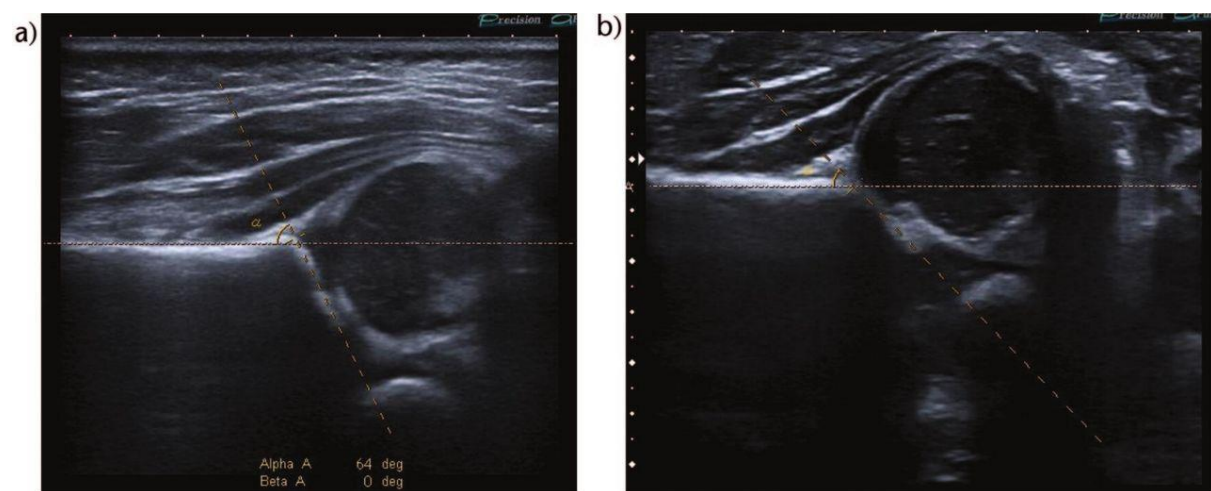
(a) Normal sonography. (b) In contrast with (a), the angle is $<60^{\circ}$ and the hip is subluxated.
